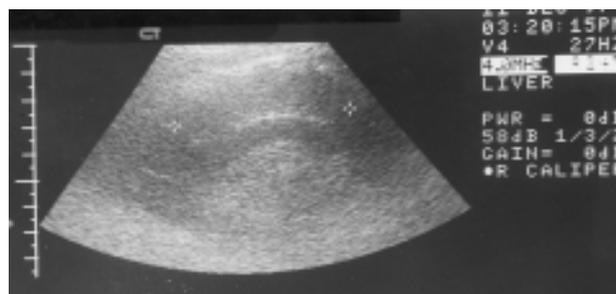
Ultrasonography showing hypo-echogenicity of the pancreas compatible with inflammation or oedema.
